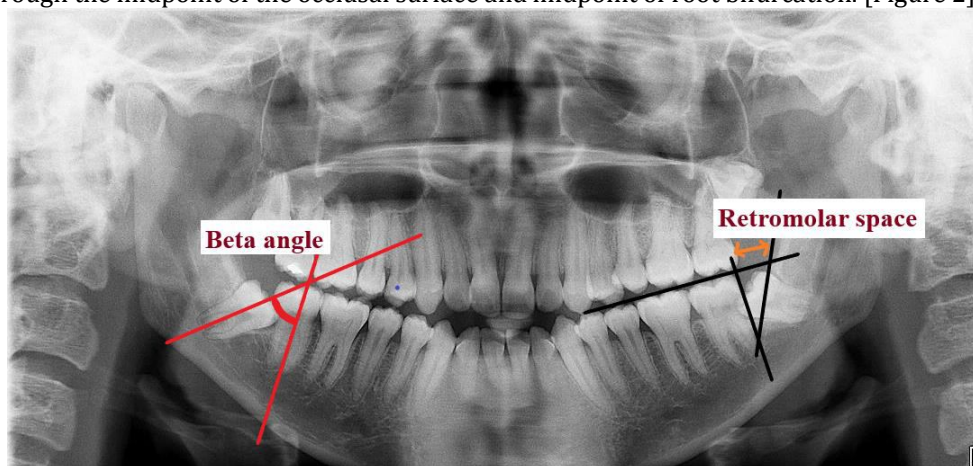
Measurement of retromolar space and β angle on orthopantomogram
